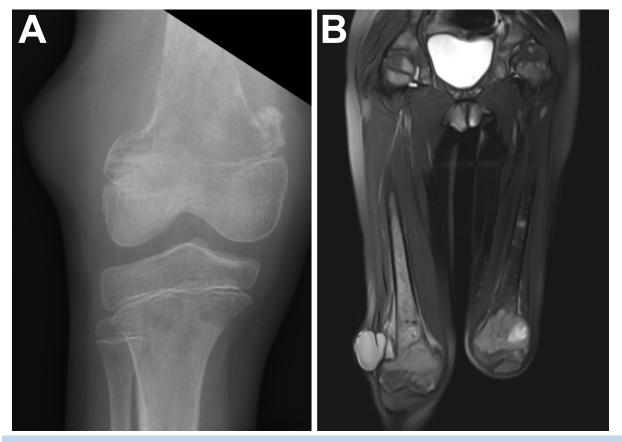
(A) X-ray of her right knee on hospital admission. Minimally displaced fracture of the distal metadiaphysis is visualized. Associated soft tissue swelling secondary to hematoma and moth-eaten appearance of metastatic lesion is also seen in femur diaphysis and tibia. (B) MRI of the bilateral lower extremities revealing significant disease burden and acute process in the right distal femur demonstrating pathologic fracture, adjacent hematoma and suspected bone infarction in the right femur shaft.
